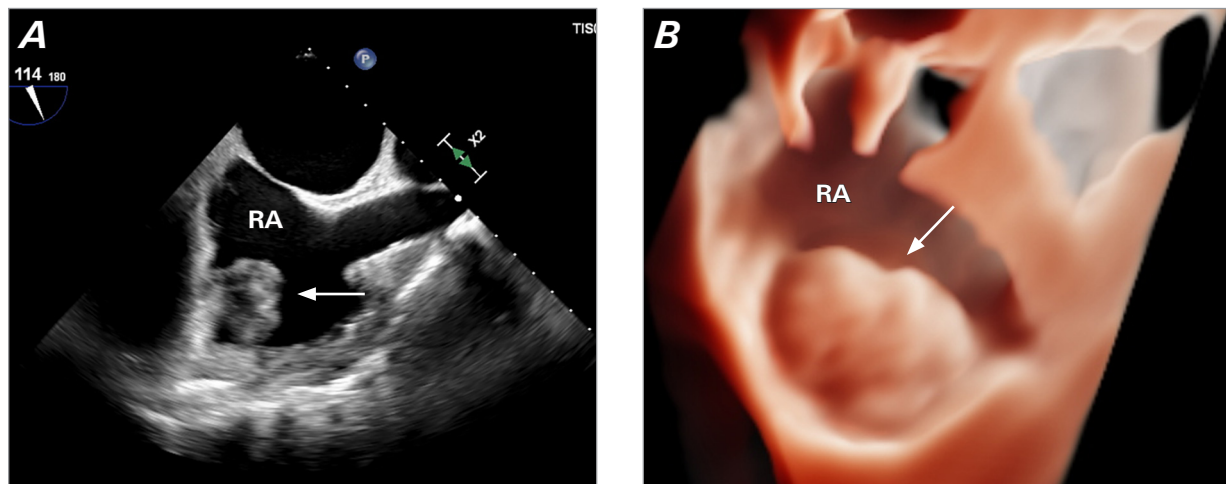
A) Two-dimensional and B) 3-dimensional transesophageal echocardiogram performed before cardioversion at initial presentation reveals an irregular 3.2 × 3-cm echogenic mass (arrow) attached to the lateral right atrial wall just above the tricuspid annulus.
